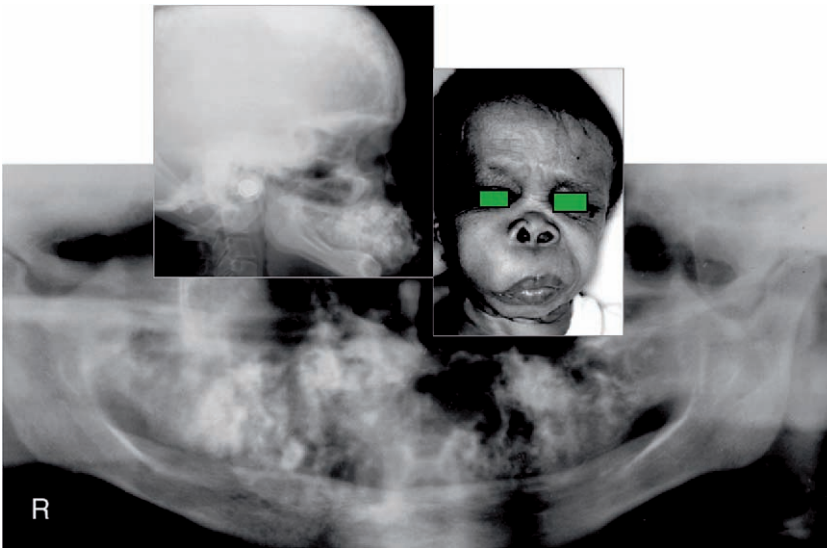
Paget disease of bone. Note cotton-ball radio-opaque sclerotic deposits. There is maxillary cortical expansion. The lesion is bilateral, crossing the midline (panoramic and lateral skull radiographs)
